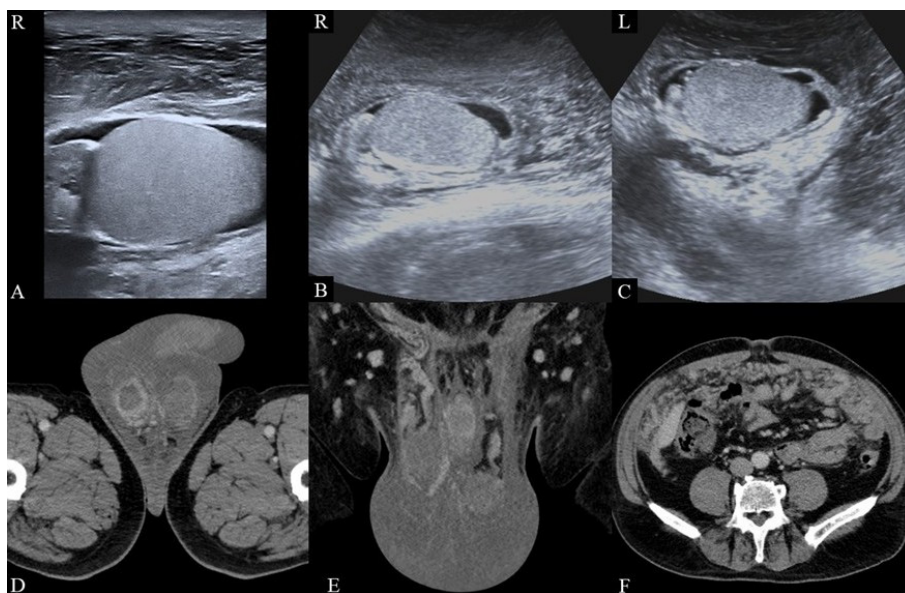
A, B, C) Ultrasound of the testicles and scrotum with linear (a) and curvilinear (b, c) probes reveals marked thickening of the scrotal walls, symmetric testicles, and a small bilateral hydrocele. D, E) Contrast-enhanced pelvic CT confirms scrotal wall thickening and subcutaneous tissue thickening at the penile base. The inner scrotal wall shows contrast enhancement, more prominent on the right, with no fluid collections or other abnormalities. F) Pelvic CT scan shows findings suggestive of an omental cake. (R - right; L - left).
